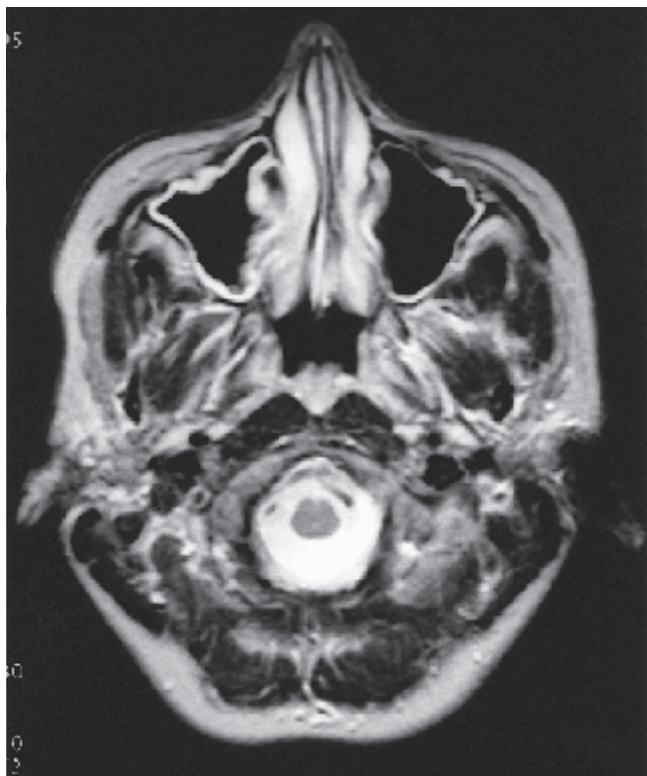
Axial MRI scan demonstrating mucosal thickening.
